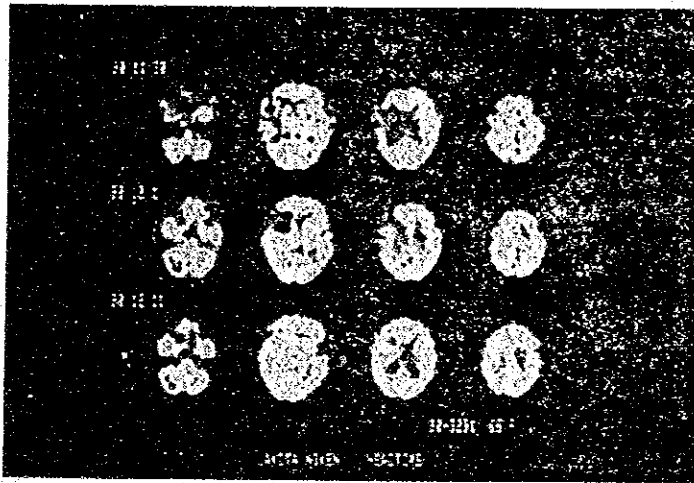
Follow-up study after embolectomy. SPECT images using ^{99m}Tc -HM-PAO
